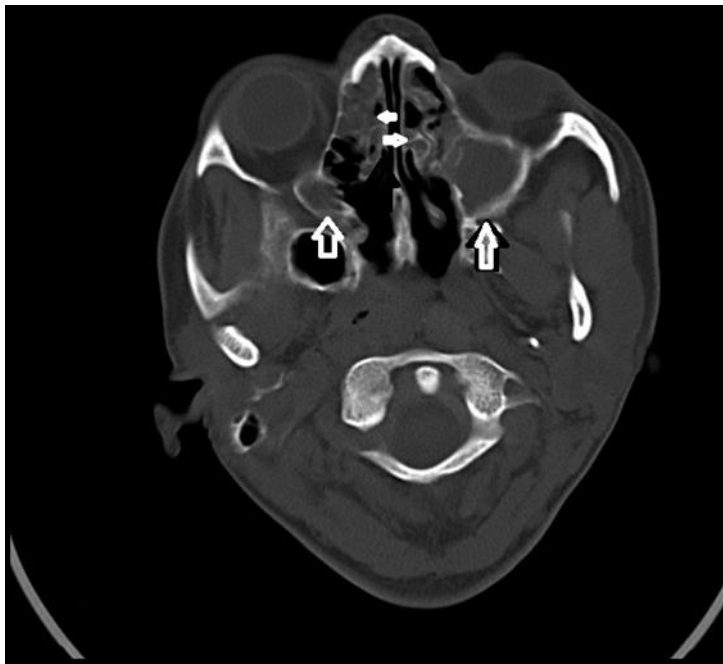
Bone window axial non-contrast enhanced CT of the brain
